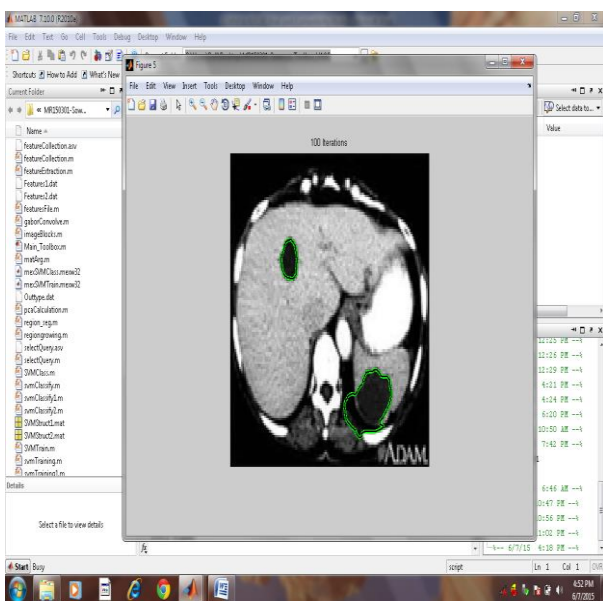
Final result showing tumor part in the CT image
